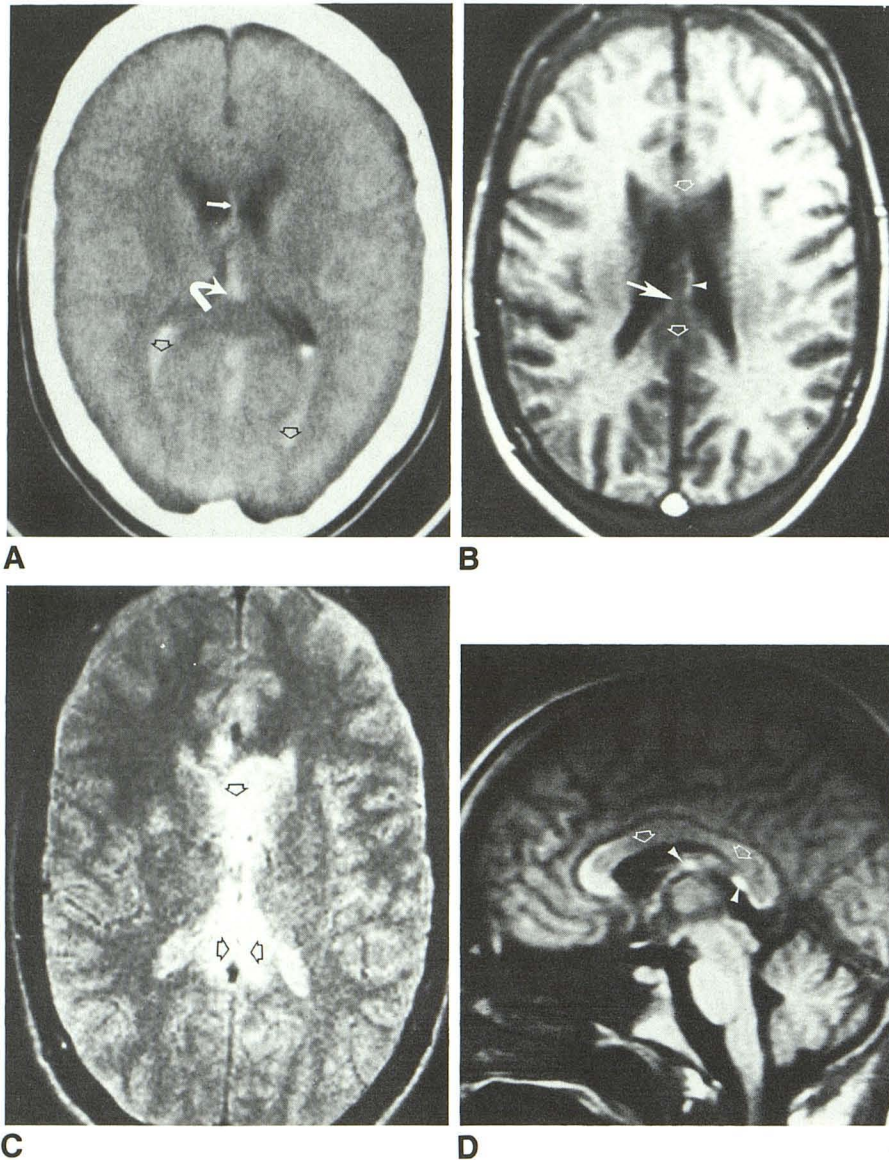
A, Axial CT scan reveals intraventricular hemorrhage (*open arrows*); small area of hemorrhage in septum pellucidum (*straight solid arrow*); and blood near junction of corpus callosum, fornix, and septum pellucidum (*curved arrow*). No definite lesions, however, are seen within corpus callosum.
